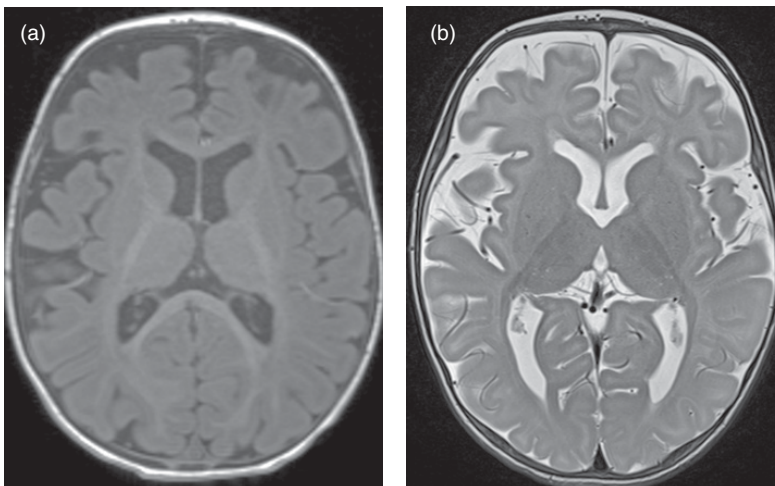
A 6-month-old infant with choreiform movements, developmental delay, elevated CSF succinyladenosine, and pathogenic mutations in adenylosuccinate lyase. (a) Axial T1 and (b) axial T2 images demonstrate a moderate prominence of the subarachnoid spaces and a mild prominence of the ventricles, consistent with low volume. Myelination was within range for age. There were no patterns of signal abnormality to suggest a specific diagnosis radiographically.
